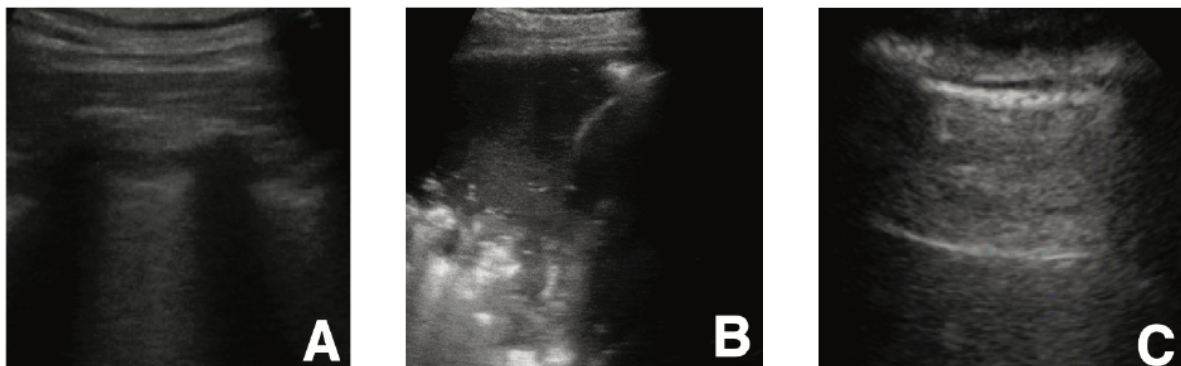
“Example lung ultrasound images. (A): A typical COVID-19 infected lung, showing small subpleural consolidation and pleural irregularities. (B): A pneumonia infected lung, with dynamic air bronchograms surrounded by alveolar consolidation. (C) Healthy lung. The lung is normally aerated with horizontal A-lines.” Image and caption from Born et. al. 2020 [1]
